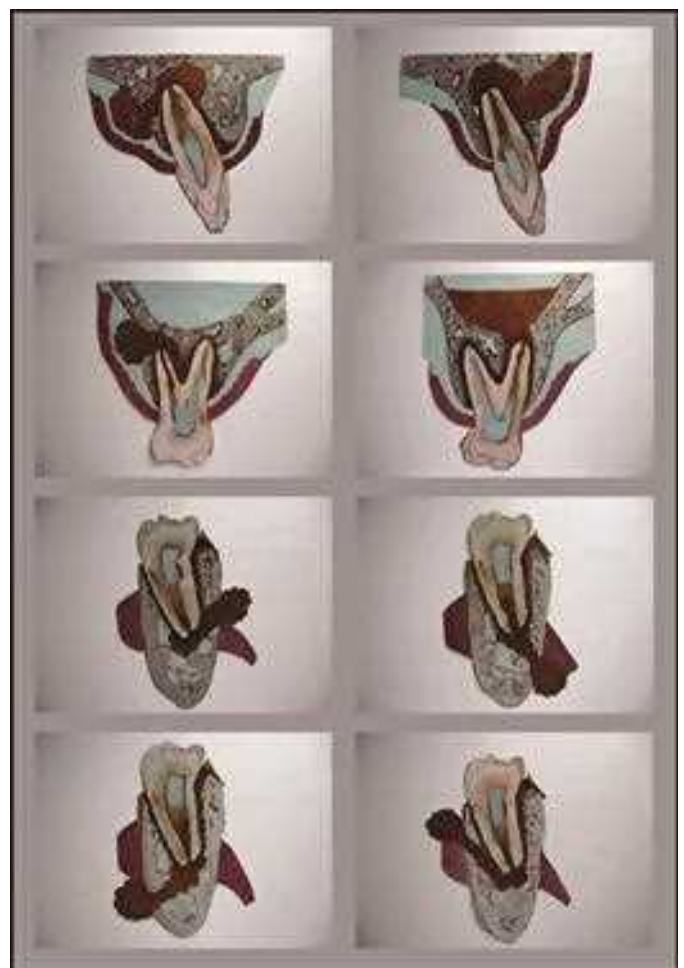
Possible paths of spread of infection from acute periapical abscess.
